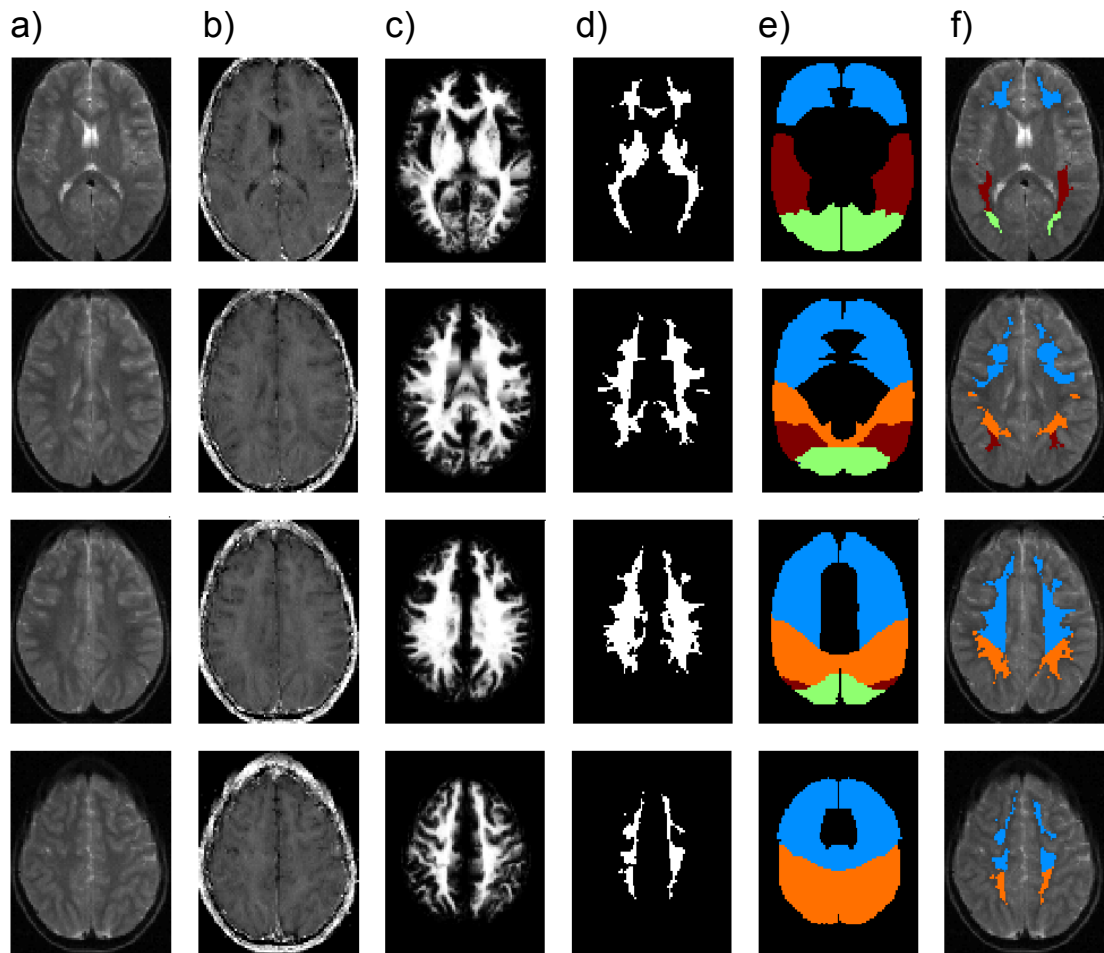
a) T2-weighted images, b) R2 maps, c) white matter probability maps, d) white matter mask, e) Lobar ROIs f) white matter mask intersected with lobar ROIs overlaid onto T2-weighted image.
